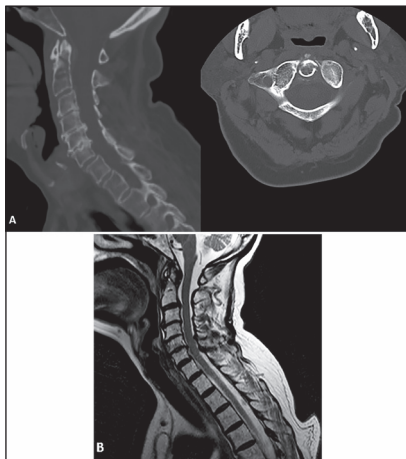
81-year-old female status post fall who sustained a type II dens fracture. At time of injury: (a) Sagittal and axial computed tomography scan, and (b) Sagittal T2-weighted images demonstrating C2 fracture
